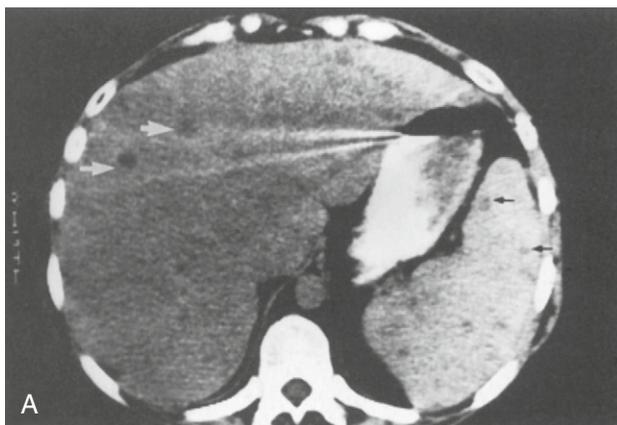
Candida* hepatic, splenic and renal abscesses in an immunosuppressed leukemic patient. (A) Non-enhanced CT scan through the upper abdomen demonstrates multiple small, round hypodensities (arrows) in the liver and spleen. (B) Enhanced CT scan shows low-density lesions (arrows) in the liver and right kidney. (Case courtesy of Dr Isaac Francis, Ann Arbor, MI.)
